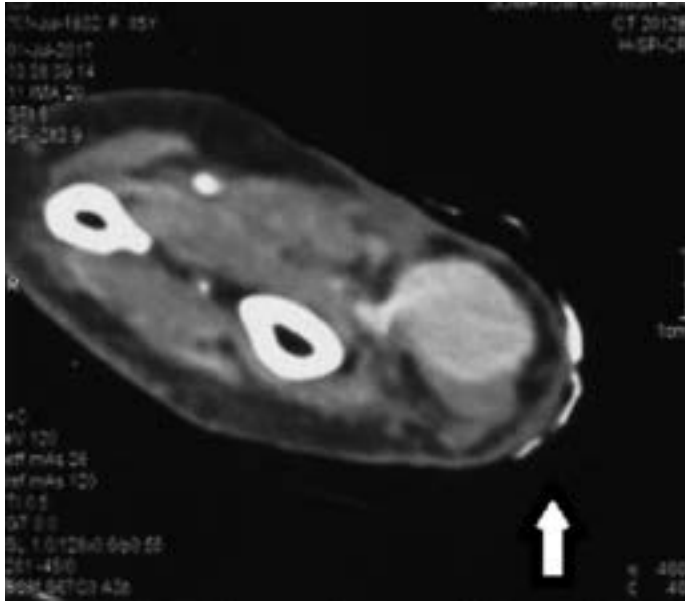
The CT angiogram showing the radial pseudoaneurysm.
